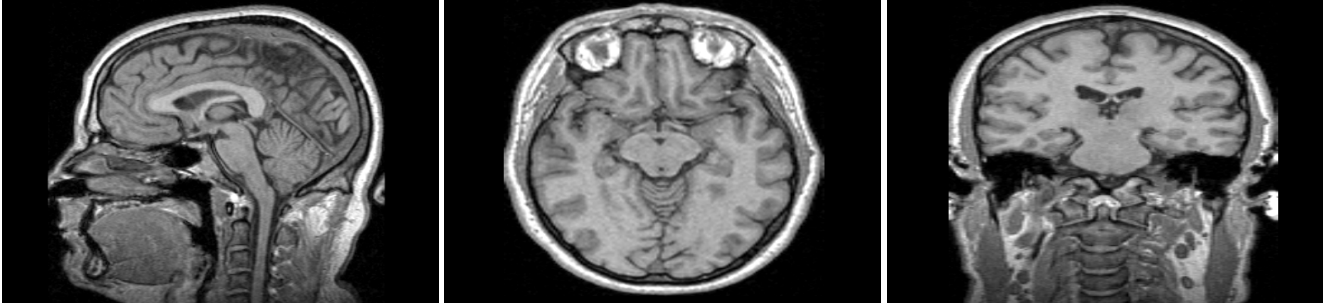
Examples of DICOM slices for a brain MRI representing the Sagittal, Axial, and Coronal representations, respectively. Each representation consisted of 250 slices at a slice depth of 1mm.
